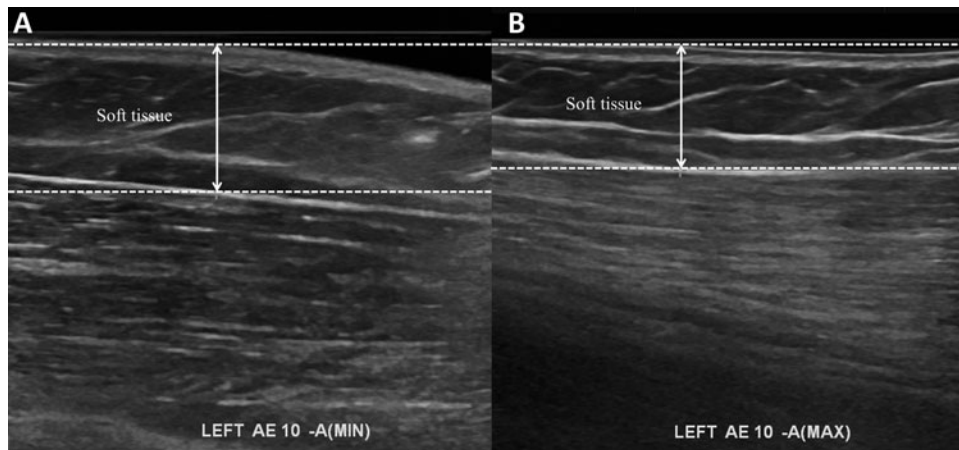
Ultrasonographic images of the arm of a change in thickness between the (A) initial soft-tissue thickness and the (B) thickness after applying maximal pressure.
